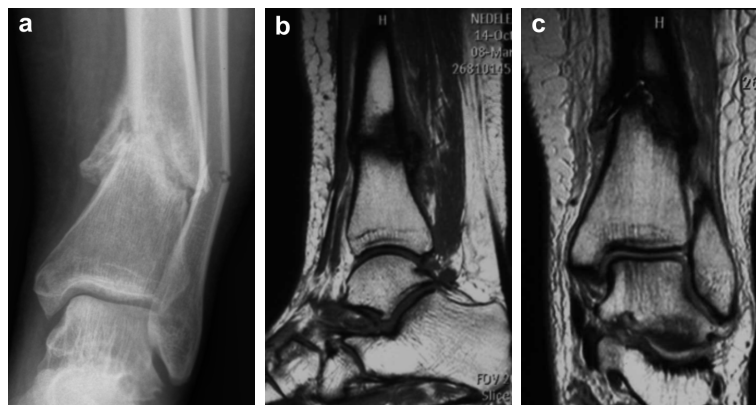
(a) Preoperative X-ray showing fracture of the distal tibia and peroneum with angulation of the fragments, occurred on a bone cyst, limited by sclerotic bone; (b and c) MRI showing the limiting sclerotic bone and the benign aspect of the injury.
